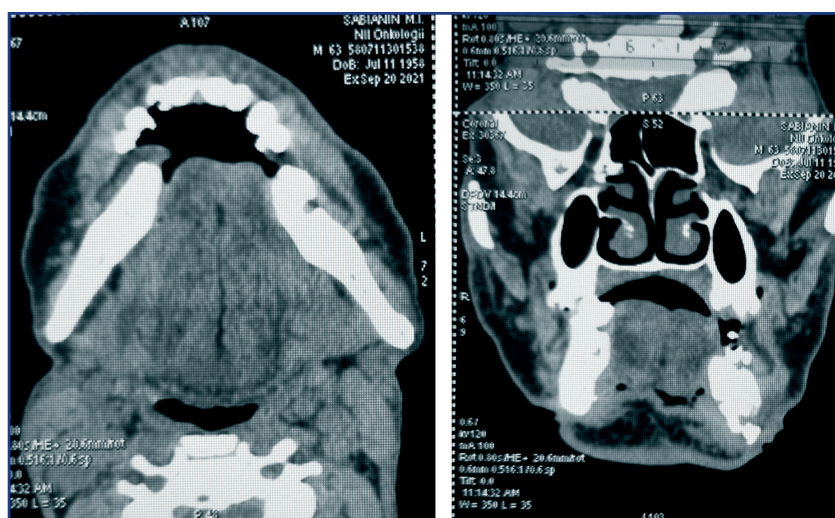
CT picture of the condition after complex treatment for skin cancer on the chin
